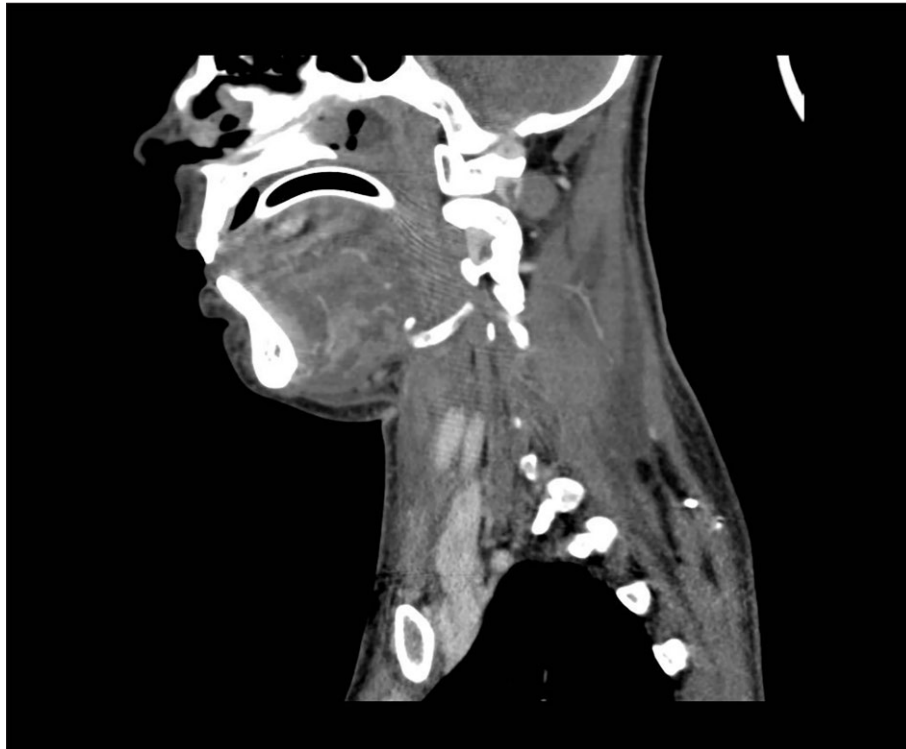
A CT scan of head and neck showing soft tissue swelling and airway obstruction.
